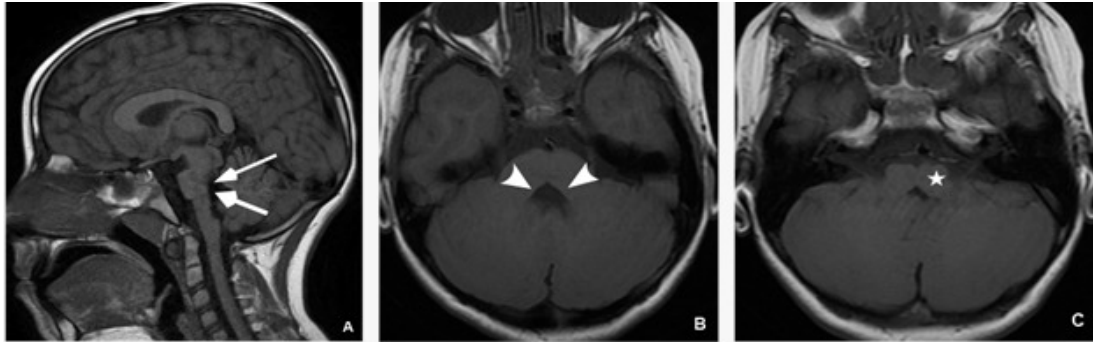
A. On sagittal T1 MRI the followings are seen; the depression on the fourth ventricular base (arrow) and the reduced medulla and pons diameters. B. The midline cleft in Pons (arrow) and the absence of the surface contour of the facial collicules. C. On axial T1 MRI the butterfly-like configuration of the medulla.
